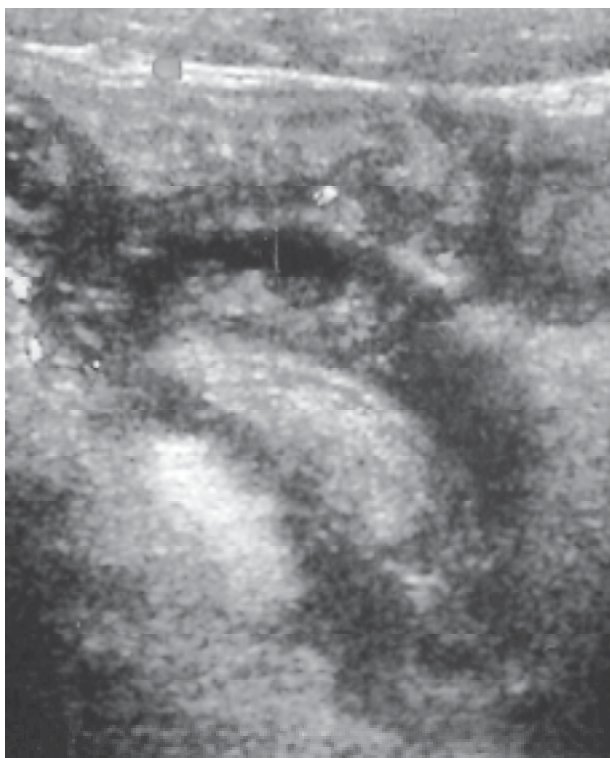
Perforated appendicitis: longitudinal scan through the perforated appendix with neighboring hypoechoic collection; color-flow Doppler shows inflammatory hypervascularization of the periappendicular tissue.
